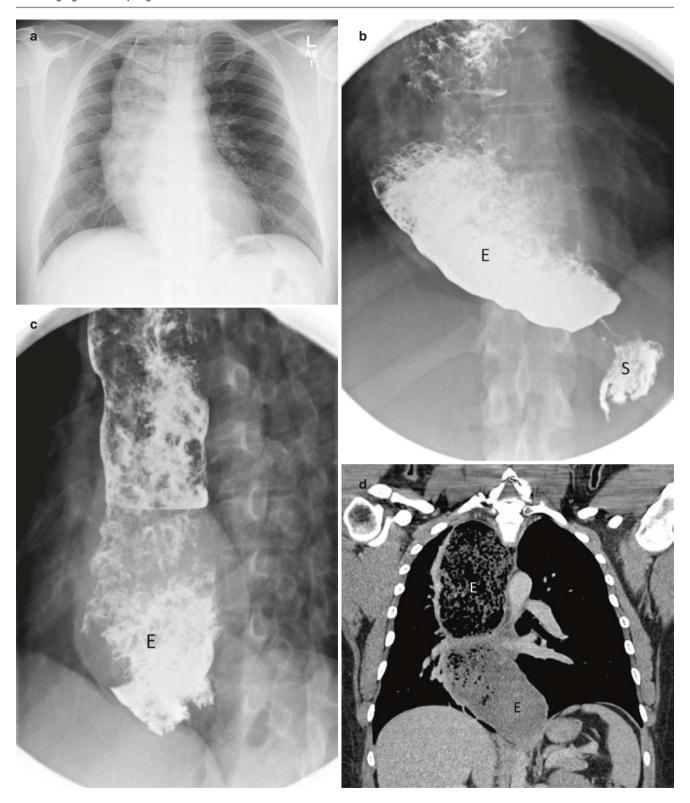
A 25-year-old man with recurrent chest pain due to achalasia cardia. (a) Frontal radiograph shows a large mediastinal mass with mottled densities in keeping with a dilated esophagus. $(b,\ c)$
